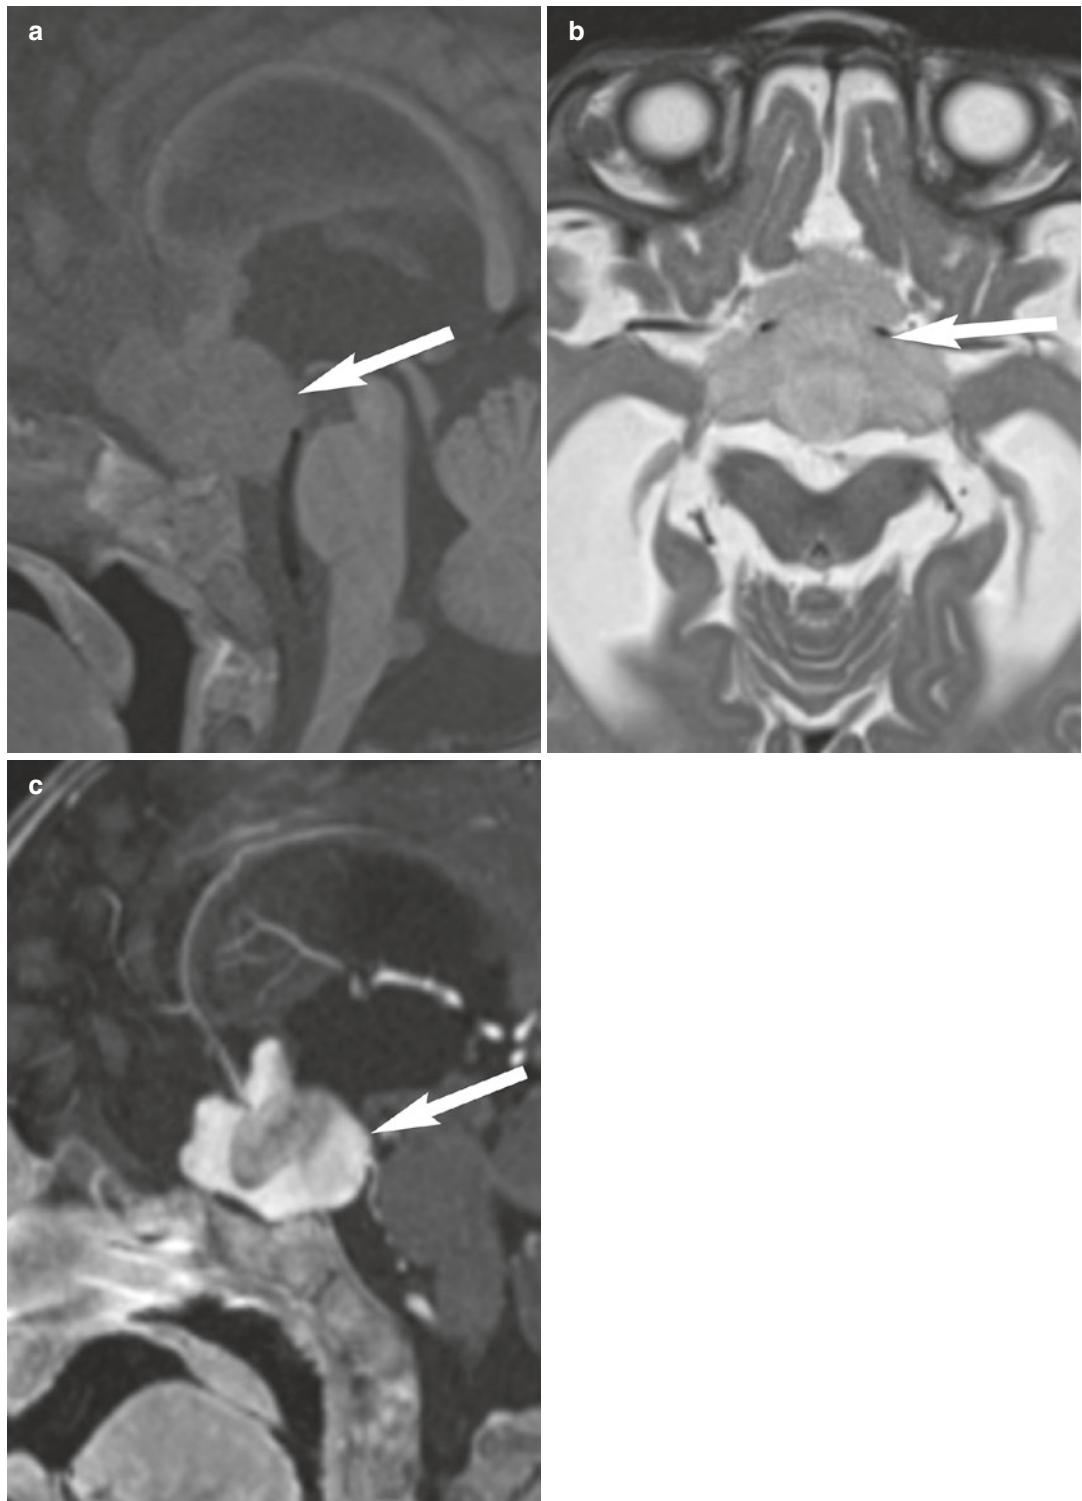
Hypothalamic-chiasmatic glioma. A 7-year-old male with NF-1. Sagittal (a) unenhanced T1-weighted and axial (b) T2-weighted images show large lobulated mass centered in the suprasellar region with extension into
